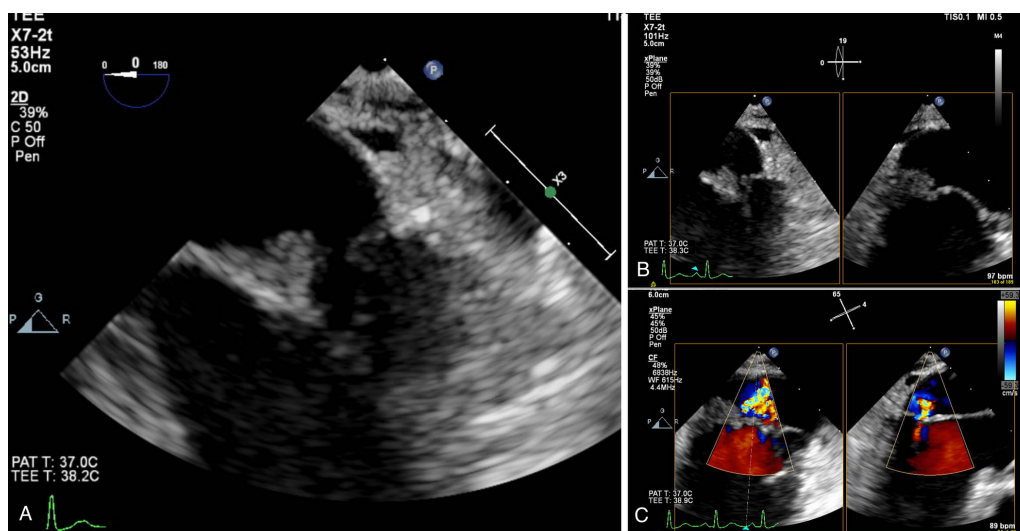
(A and B) Transoesophageal echocardiography showing a 1.1×0.7 cm vegetation on the posterior leaflet of the mitral valve. (C) The presence of mitral valve regurgitation.
